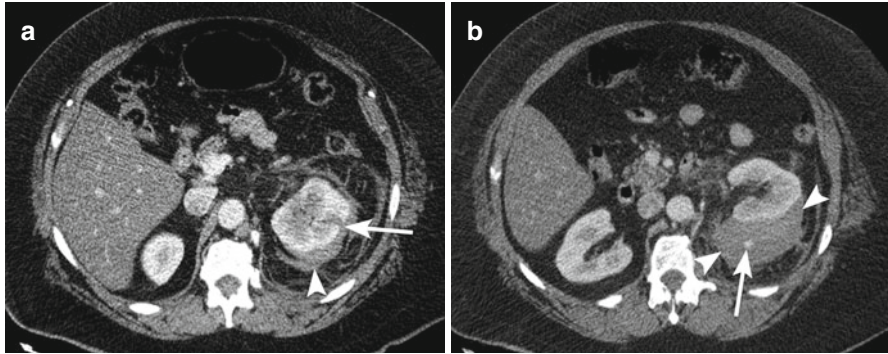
Kidney laceration and bleeding. (a) Contrast-enhanced computed tomography (CT) demonstrates a linear defect (*arrow*) through the lateral renal cortex consistent with a laceration. Note the surrounding hematoma (*arrowhead*) in the perinephric space. (b) More inferiorly, there is a focus of active arterial hemorrhage (*arrow*) into the perinephric hematoma (*arrowheads*)
